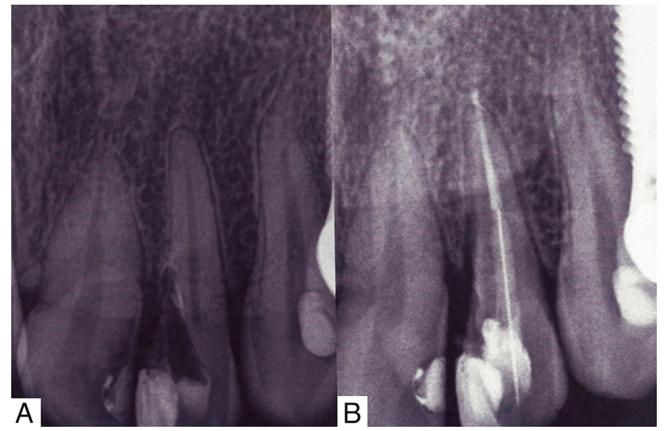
(A) Preoperative and (B) postoperative radiography of tooth 22 (maxillary left lateral incisor) with a cervical perforation filled with Biodentine.
